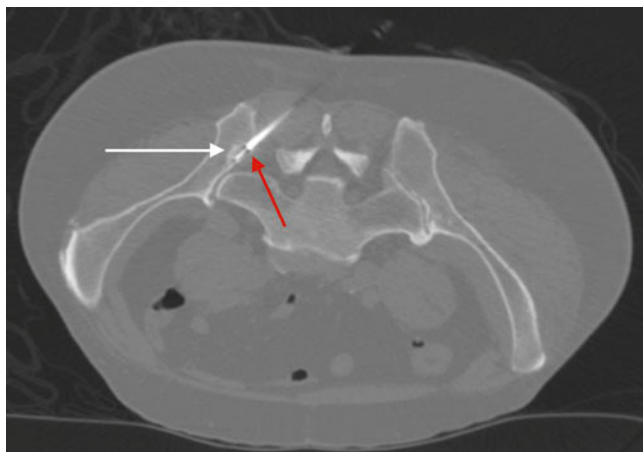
CT-guided bone biopsy. This figure shows biopsy of the right ischial tuberosity with an 18 gauge biopsy needle. The white arrow denotes a sclerotic lesion within the bone. The red arrow points to the needle. As in Fig. 30.2, there is a gap between the end of the needle and the area of the needle denoted by the red arrow. This is the portion of the needle that procures the sample tissue
